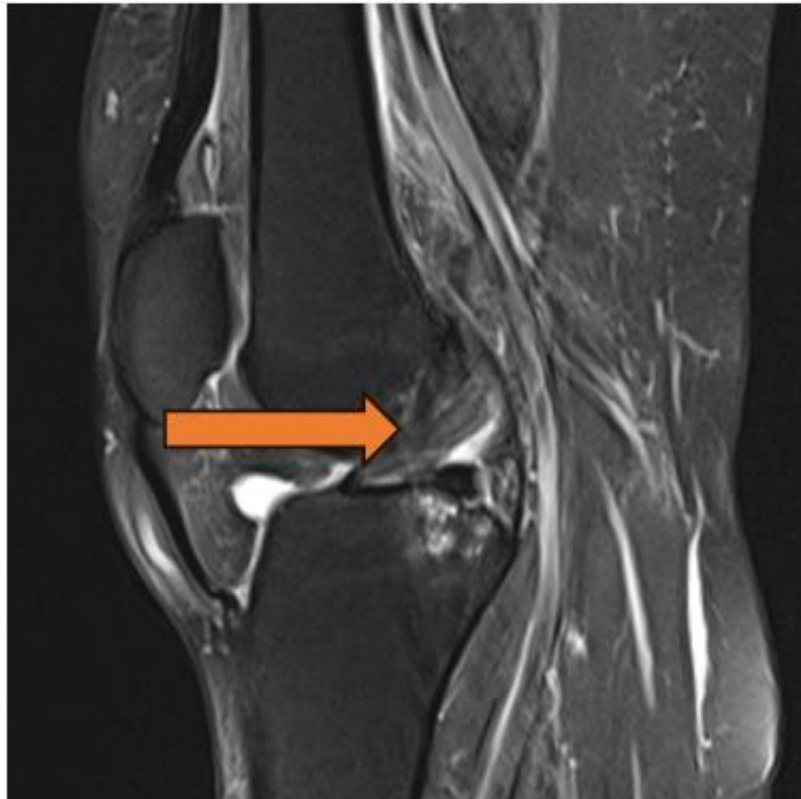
MRI Right knee joint PDFS sequence, sagittal section shows intrasubstance hyperintensities of the anterior cruciate ligament, consistent with ACL sprain
